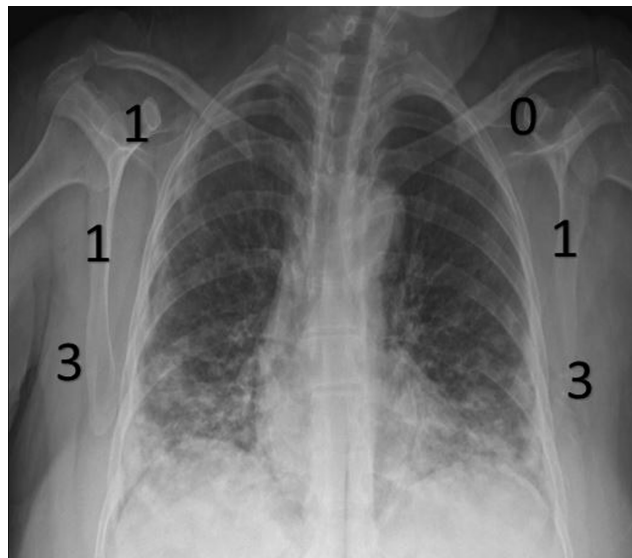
Example of the chest X-ray (CXR) scoring system in patients with coronavirus disease 2019 (COVID-19) pneumonia. CXR Score: 9.
